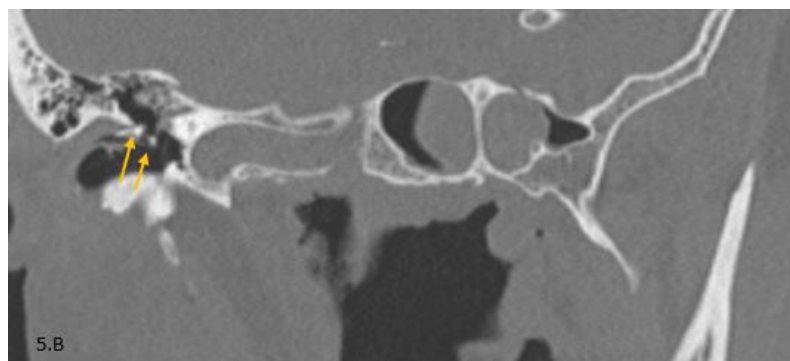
B: right coronal oblique CT view, bone window revealed disruption of the ossicular chain (yellow arrows).
